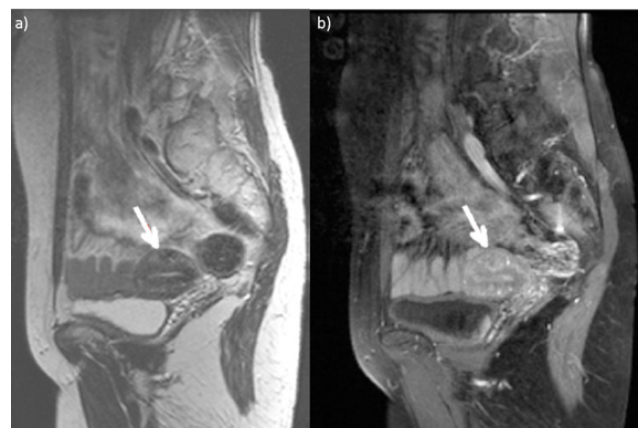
Pelvic MRI: a) T2W image and b) T1W C+ image show a normal uterine anatomy (arrows).
